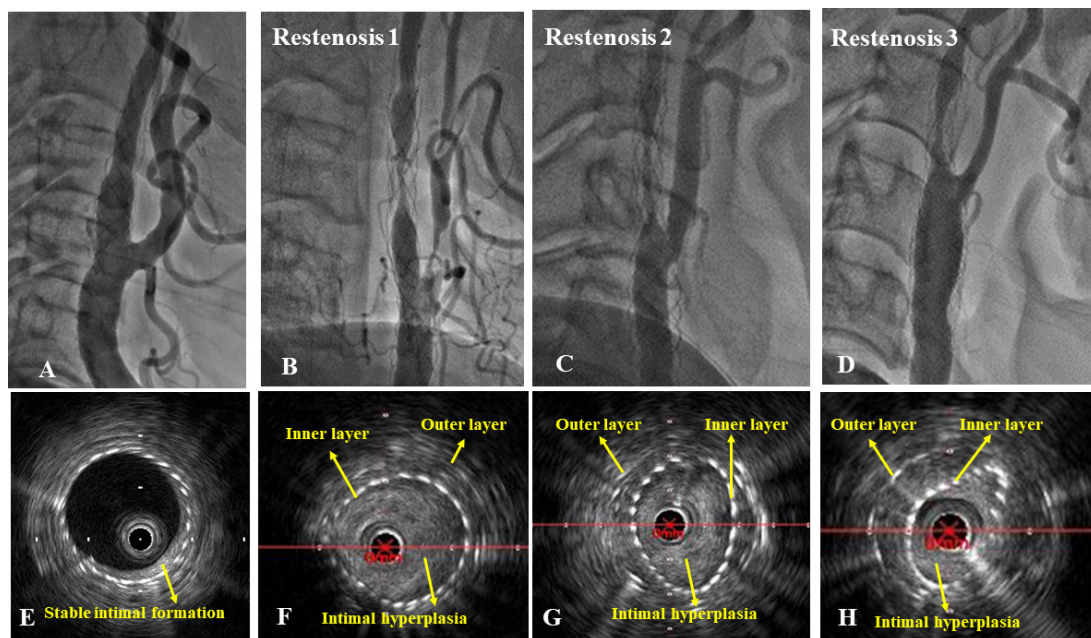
Good progress case (A,E). Follow-up angiography 6 months after carotid artery stenting (CAS) showing good dilatation of the stent. Intravascular ultrasound (IVUS) showing intimal formation of appropriate thickness on the inner surface of the stent. Restenosis cases (case 1: B and F, case 2: C and G, case 3: D and H). Follow-up angiography 6 months after CAS showing severe restenosis (B,C,D). IVUS findings at the narrowest portion showing that intimal proliferation is observed between the inner and outer layers of the stent, and the inner layer is dissociated from the outer layer due to intimal hyperplasia (F,G,H) and deformed (G,H).
